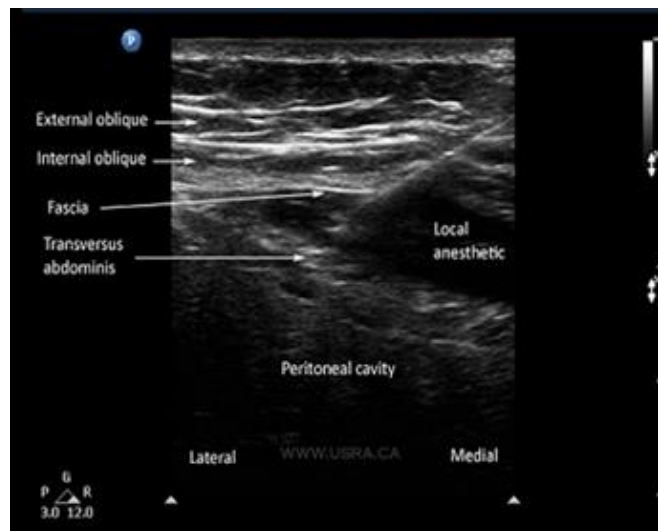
ultrasound image of the approach to transversus abdominis muscle.
